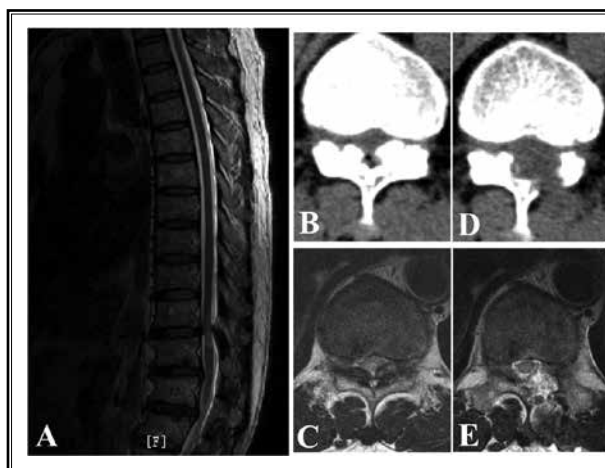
Preoperative T2-weighted MRI of the thoracic spine showed spinal cord was compressed by low-signal masses at the level of T10/11 in the sagittal section (A). The axial plane of MRI showed the spinal cord compression was caused by the low-signal masses attached to the bilateral lamina (C), which were classified as the extended type at the CT scan of the thoracic spine (B). Satisfactory decompression was completed after the left laminotomy, which was confirmed by the axial planes of CT scan (D) and MRI (E).
